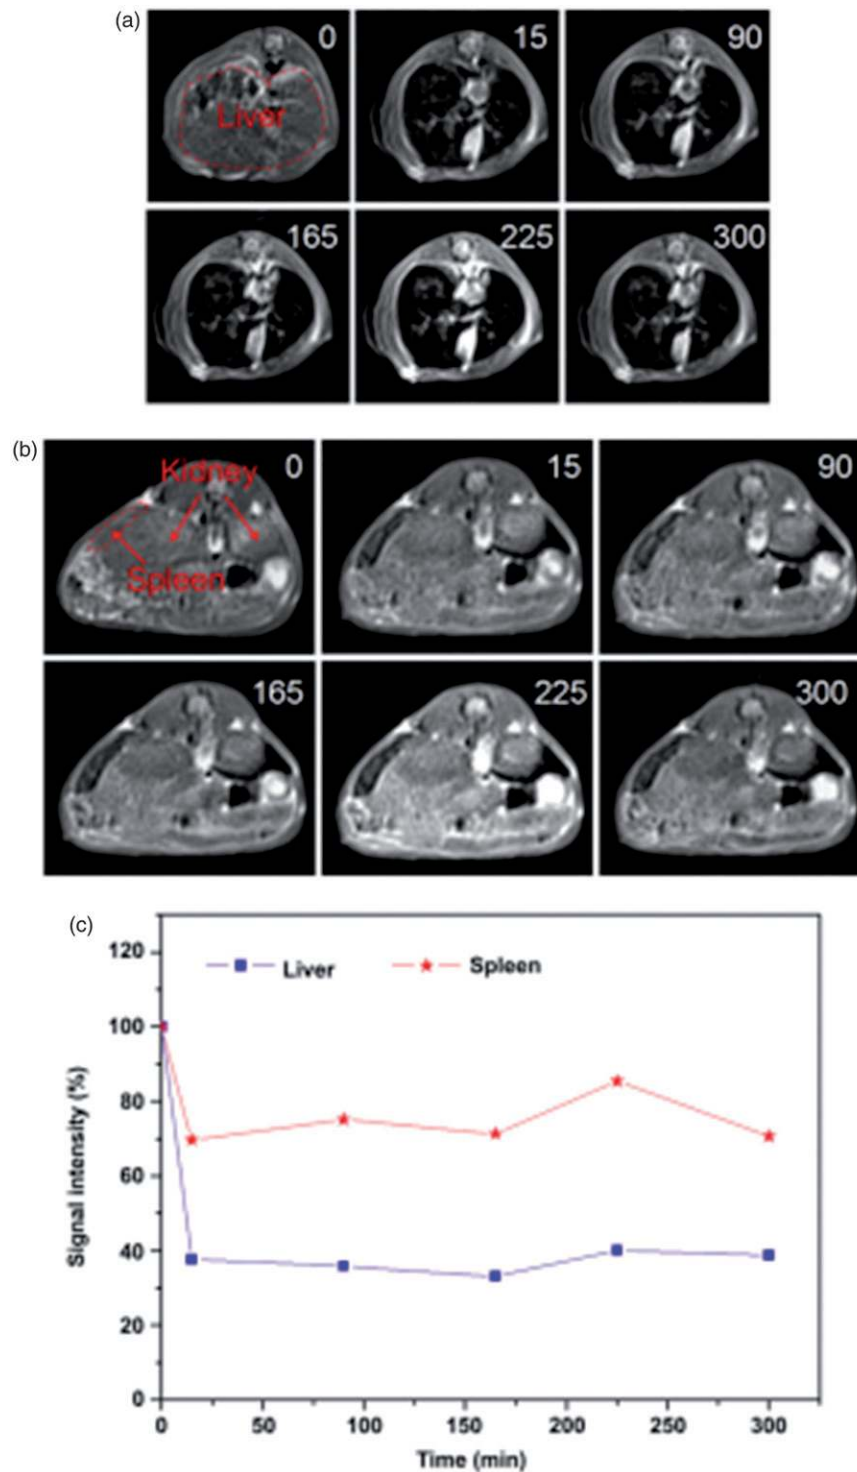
In vivo* T2-weighted MRI images of (a) liver and (b) kidneys/spleen before and after administration of MMWCNT (post 15, 90, 165, 225, and 300 min), (c) time-dependence of the relative signal intensity in liver and spleen after the administration of MMWCNT [121].
